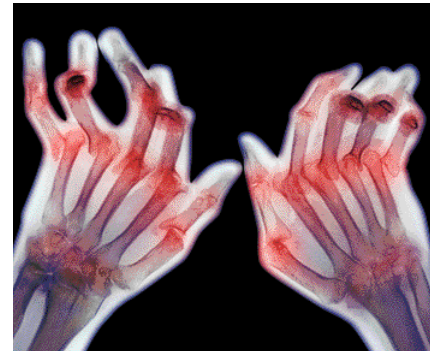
ray of arthritic hands.
